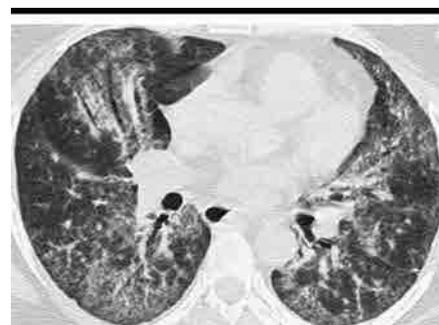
Cellular NSIP in a 50-year-old woman with shortness of breath. Transverse CT image through lower lungs shows predominantly peribronchovascular ground-glass opacity with associated reticular pattern.
